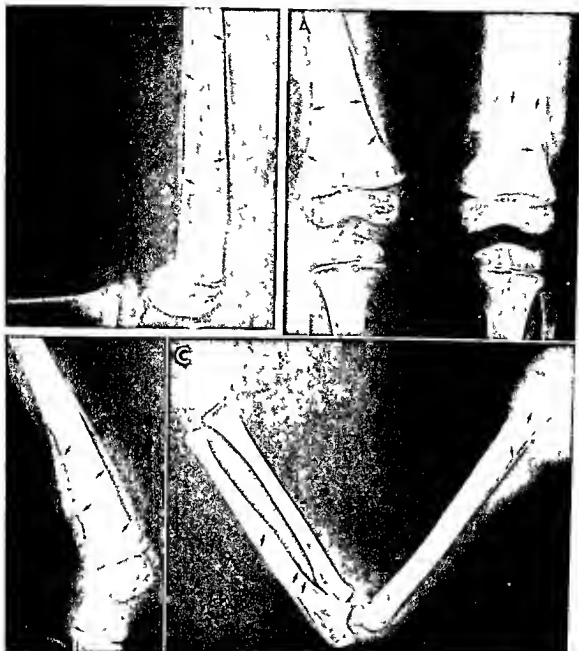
(above left) — Low grade osteomyelitis which resembles Ewing's tumor roentgenographically. In the middle third of the femoral shaft is a long segment of moth eaten destruction. The overlying cortex is thickened and lamellated.
